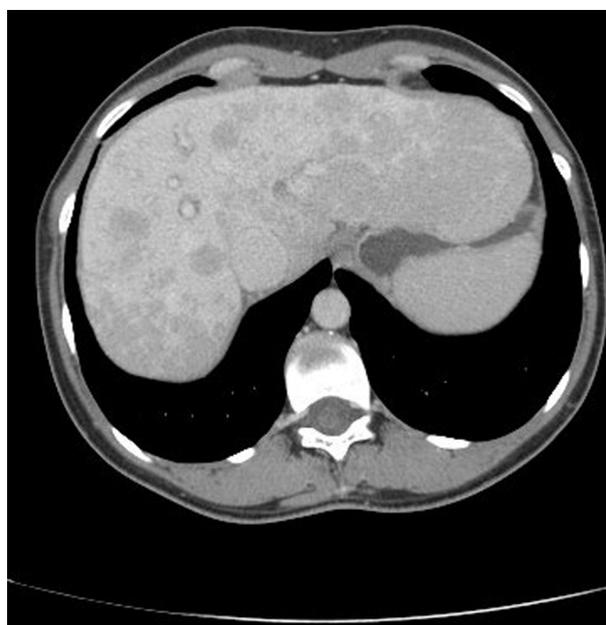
Computed tomography scan abdomen showing multiple hypodense liver lesions suspicious of liver metastasis.
